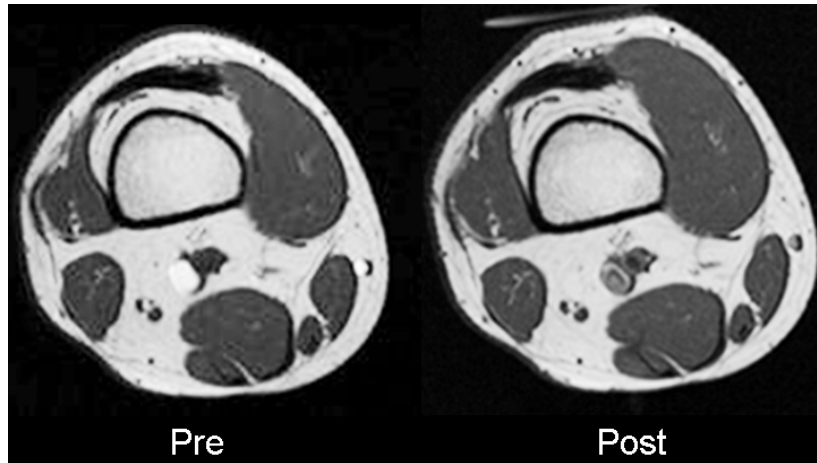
Pre and post-training MR image of the distal thigh at suprapatellar level. Images were selected from a subject of program H.
